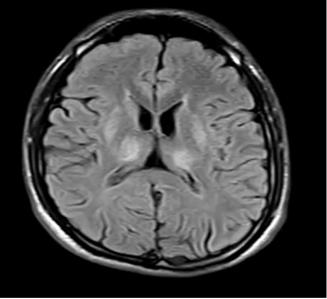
Brain MRI using T2-weighted and fluid-attenuated inversion recovery (FLAIR) sequences showing increased signal intensity in the basal ganglia, with greater involvement of the lentiform nucleus and thalamus bilaterally, without evidence of diffusion restriction. Source: Patient's medical records.
